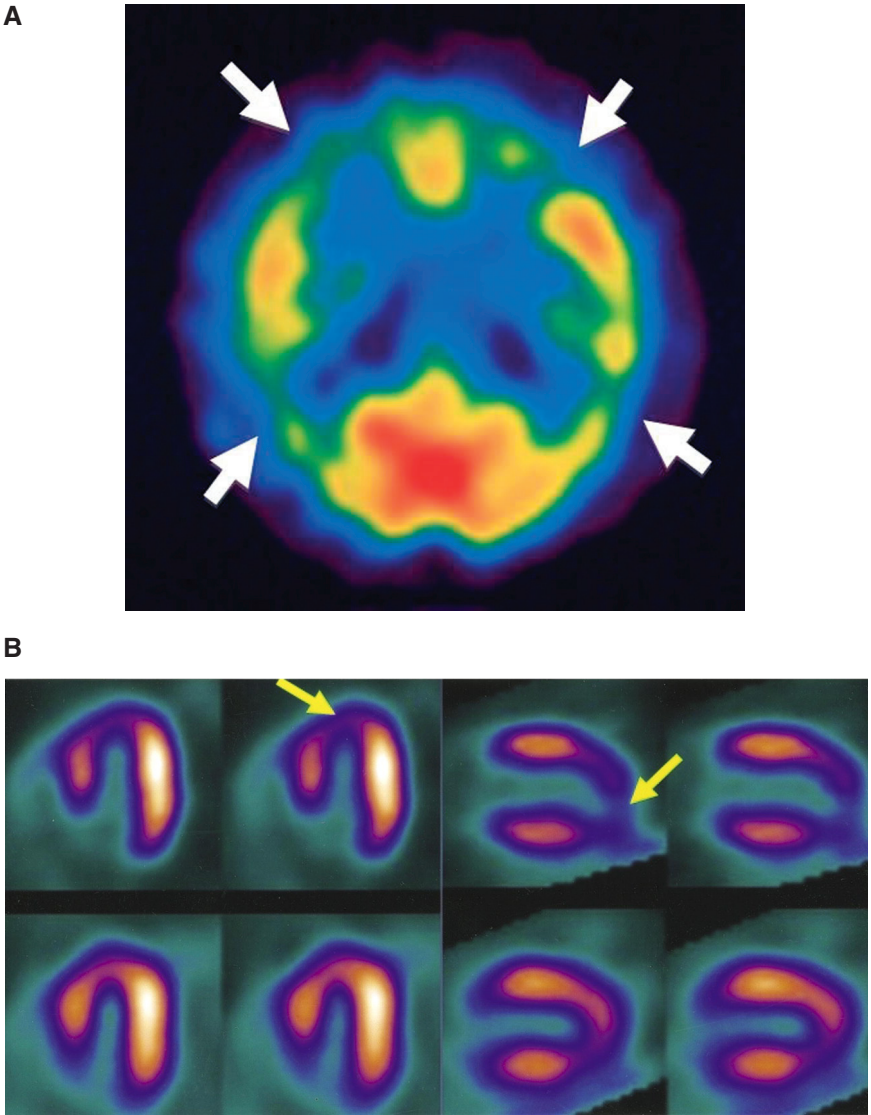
(a) Image acquired from a Tc-99m cerebral blood flow brain scan of a person with Alzheimer's disease. The arrows indicate areas of diminished blood flow due to the disease. SOURCE: Courtesy of Satoshi Minoshima, University of Washington. (b) Images acquired from a cardiac perfusion SPECT study at stress and rest using a Tc-99m radiotracer. The images on the top row are taken during stress, and the images at rest are shown on the bottom. The arrows indicate areas of decreased perfusion, visualized by the darker colors in the image. SOURCE: Reprinted with permission from Elsevier from Rispler et al., 2007.
